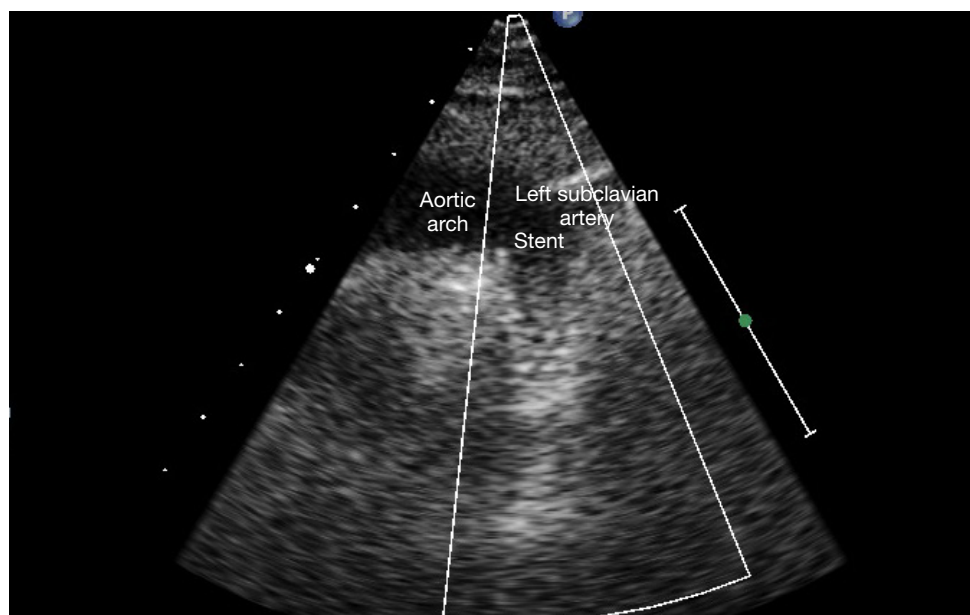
A two-dimensional transthoracic echocardiogram (suprasternal aortic arch view) showing a well deployed covered coarctation stent in the descending thoracic aorta, with prominent horizontal stent struts visible, just distal to the left subclavian artery.
